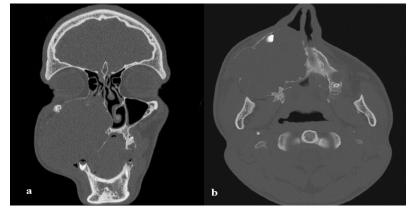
(a and b) Coronal and axial view of computed tomography showing expansile invasion
